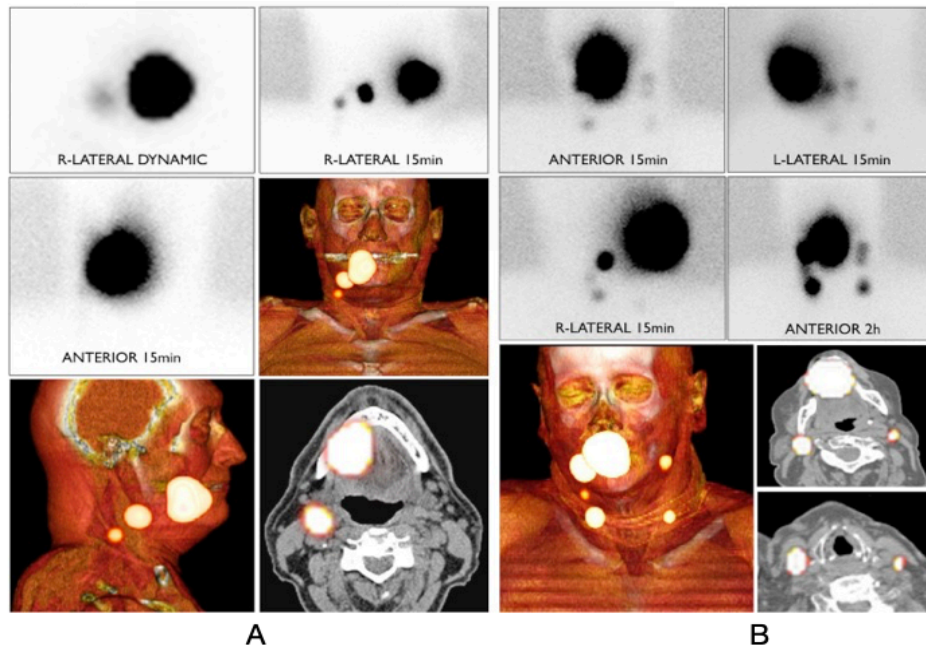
Example of SPECT/CT lymphogammagraphic study. A. Unilateral lymphatic drainage to the neck in a 55-year-old male patient with a T1 primary tumor localized on the right side of the tongue; B. Bilateral lymphatic drainage in a 72-year-old female patient with a T1 midline tongue carcinoma. *Extracted from the EANM guidelines (37).*
